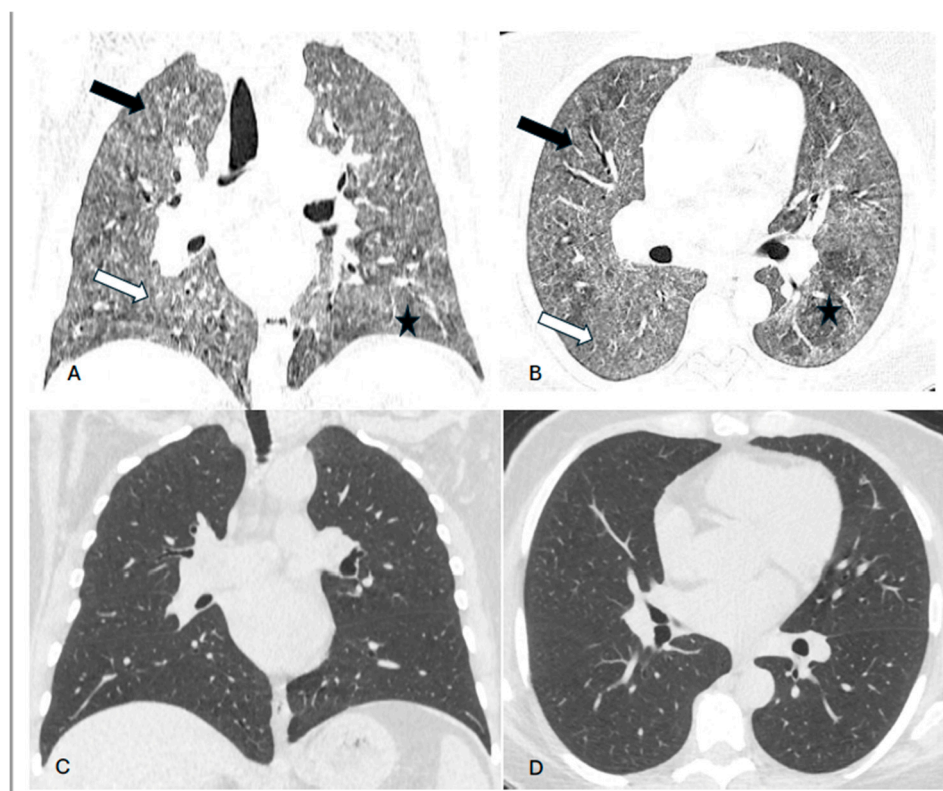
Patient 1 - High-resolution computed tomography (HRCT) scans, coronal and axial planes. A, B – baseline scans, C, D – follow-up scans. A, B: Bilateral diffuse ill-defined centrilobular nodules (black arrows), an increase in lung density with visibility of vessels and bronchial walls - ground glass opacities (white arrows) and air trapping indicating non-fibrous HP (asterisks); C, D: nearly complete regression of ground glass opacities.
